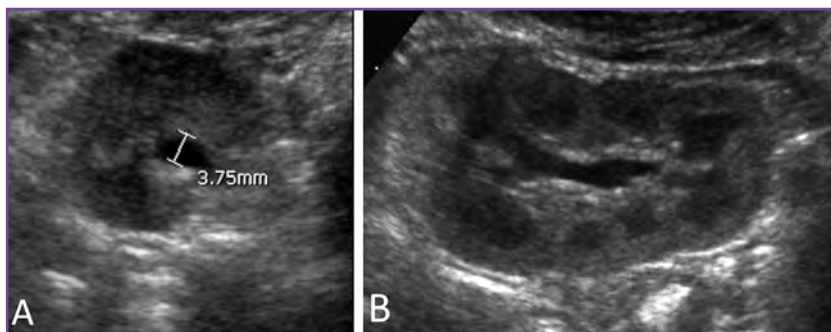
Normal postnatal ultrasonography (US) findings. A, US in the transverse plane exhibits an anteroposterior renal pelvic diameter of less than 10 mm, which is normal for age. B, US in the sagittal plane exhibits normal renal parenchyma without any dilation of the calyces. A normal bladder is not shown, and ureters are not seen.
